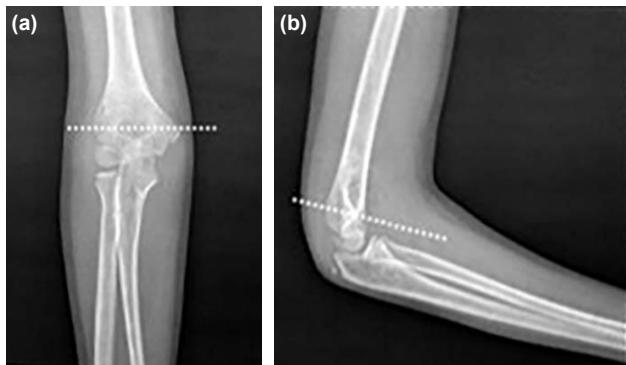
Demonstration of fracture level relative to humeral isthmus on biplanar radiograph.
